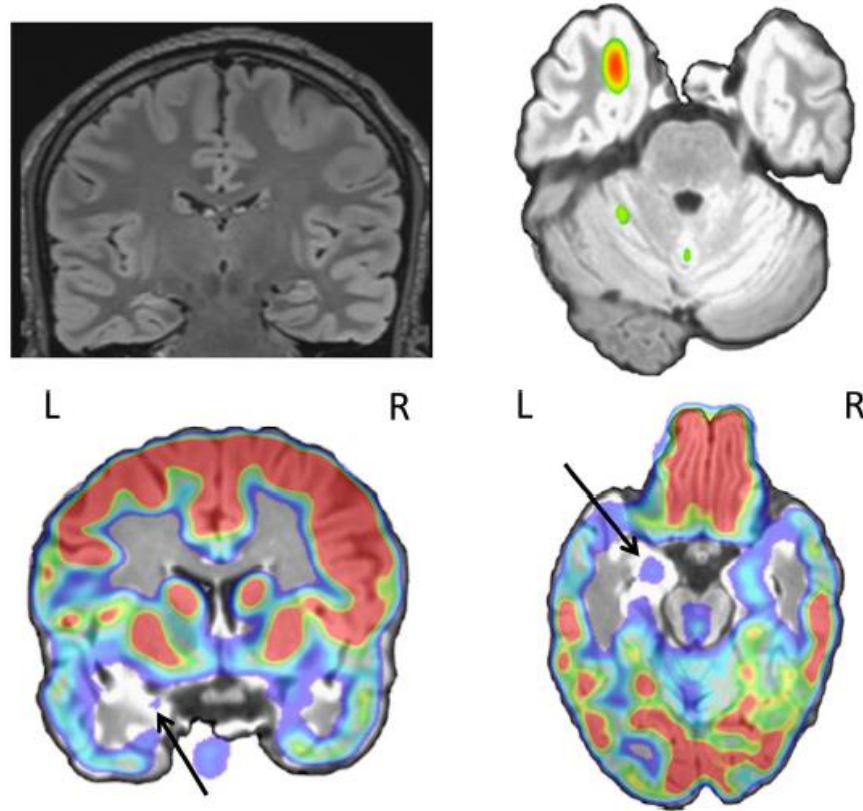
Twenty-seven-year-old patient with left mesial temporal lobe sclerosis (FLAIR sequence, coronal view) and bitemporal interictal spikes. PET showed hypometabolism on the left mesial temporal structures and temporal pole (black arrow). SISCOM showed concordant ictal hyperperfusion (maximum in the temporal pole, shown in the figure).
